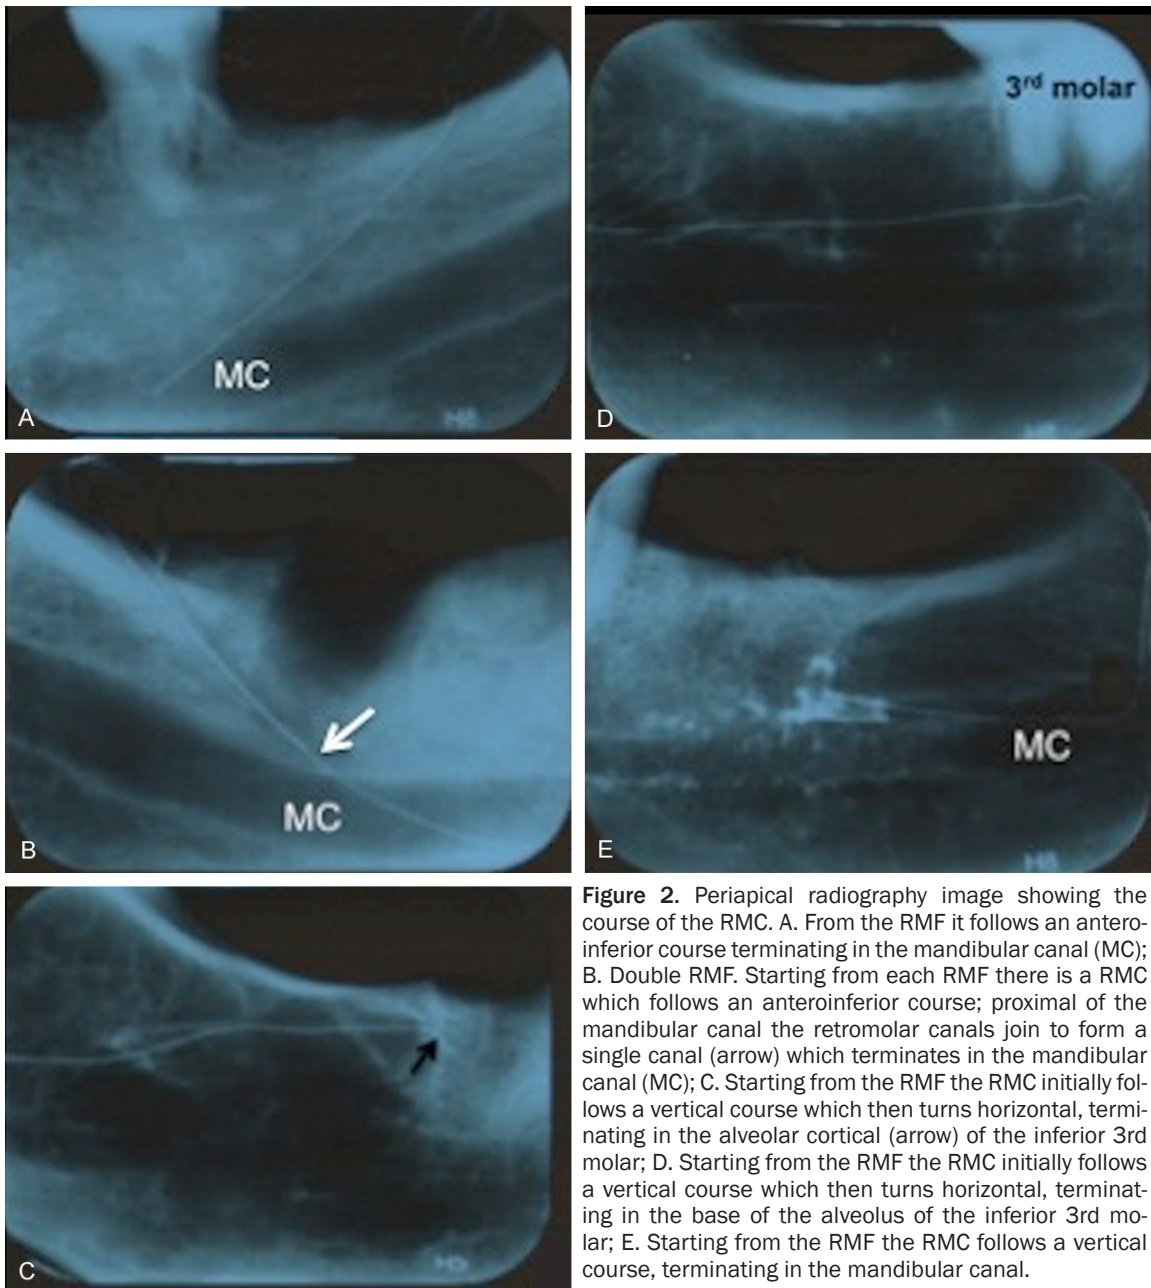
Periapical radiography image showing the course of the RMC. A. From the RMF it follows an antero-inferior course terminating in the mandibular canal (MC); B. Double RMF. Starting from each RMF there is a RMC which follows an antero-inferior course; proximal of the mandibular canal the retromolar canals join to form a single canal (arrow) which terminates in the mandibular canal (MC); C. Starting from the RMF the RMC initially follows a vertical course which then turns horizontal, terminating in the alveolar cortical (arrow) of the inferior 3rd molar; D. Starting from the RMF the RMC initially follows a vertical course which then turns horizontal, terminating in the base of the alveolus of the inferior 3rd molar; E. Starting from the RMF the RMC follows a vertical course, terminating in the mandibular canal.
